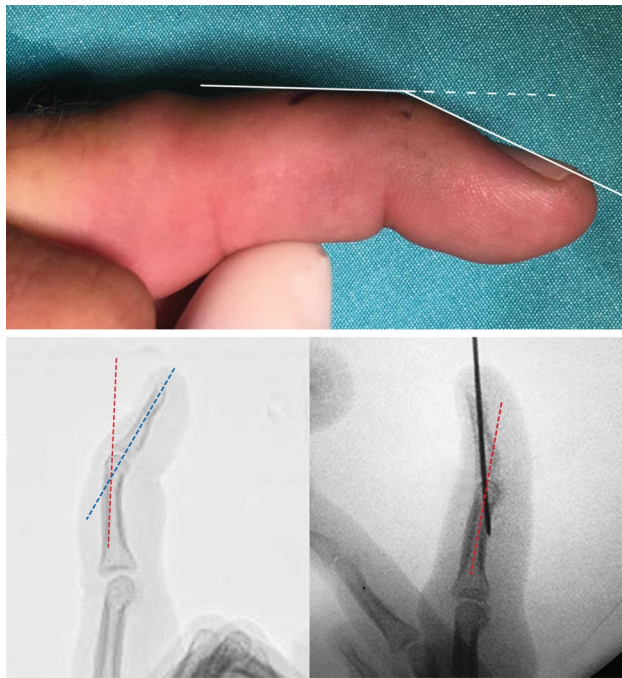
Mallet finger deformity with 25° distal interphalangeal joint active lag extension at ring finger (above). Intraoperative X-ray view of application K-wire for fixation distal interphalangeal joint in hyperextension position (below)
